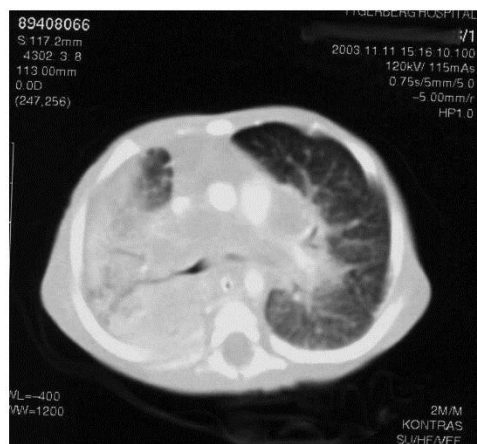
Chest computed tomograph (CT) scan of the sentinel case on admission to the intensive care unit (ICU), confirming extensive hilar adenopathy with central low attenuation, indicative of tuberculous caseation, and near-total obstruction of the right main bronchus.
